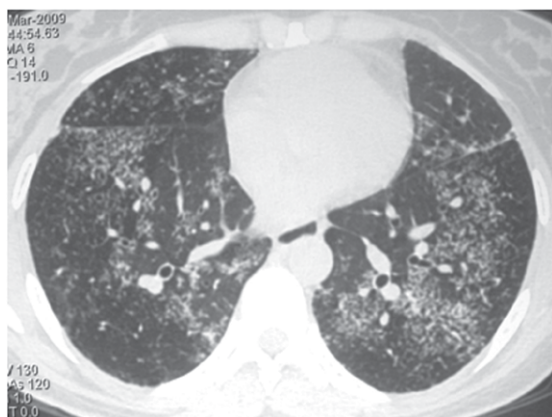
HRCT scan showing clusters of small nodules with no confluence in the lower lobes of both lungs.
